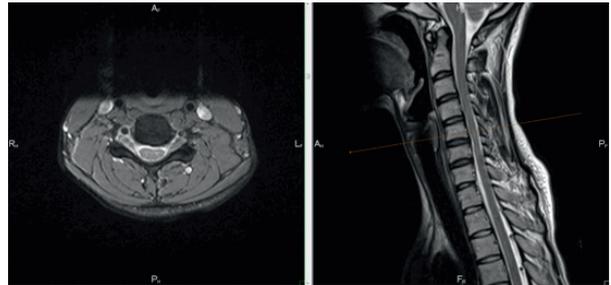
MRI - T2-hyperintensity myelopathy focus
